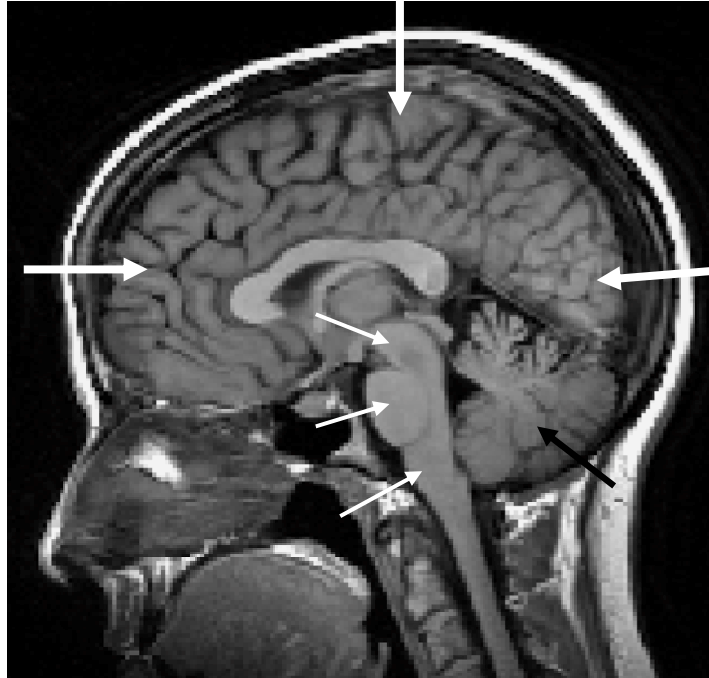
Magnetic Resonance Image of the Brain Depicting Cerebrum, Brainstem and Cerebellum (large white arrows depict cerebrum; small white arrows depict brainstem [upper midbrain, middle pons and lower medulla] and black arrows depict cerebellum. Adapted from “Magnetic Resonance Imaging Cross-Sectional Anatomy Technologist Educational Program” by L. Hoisington and S. Fedewa, 2007, p. 16.
